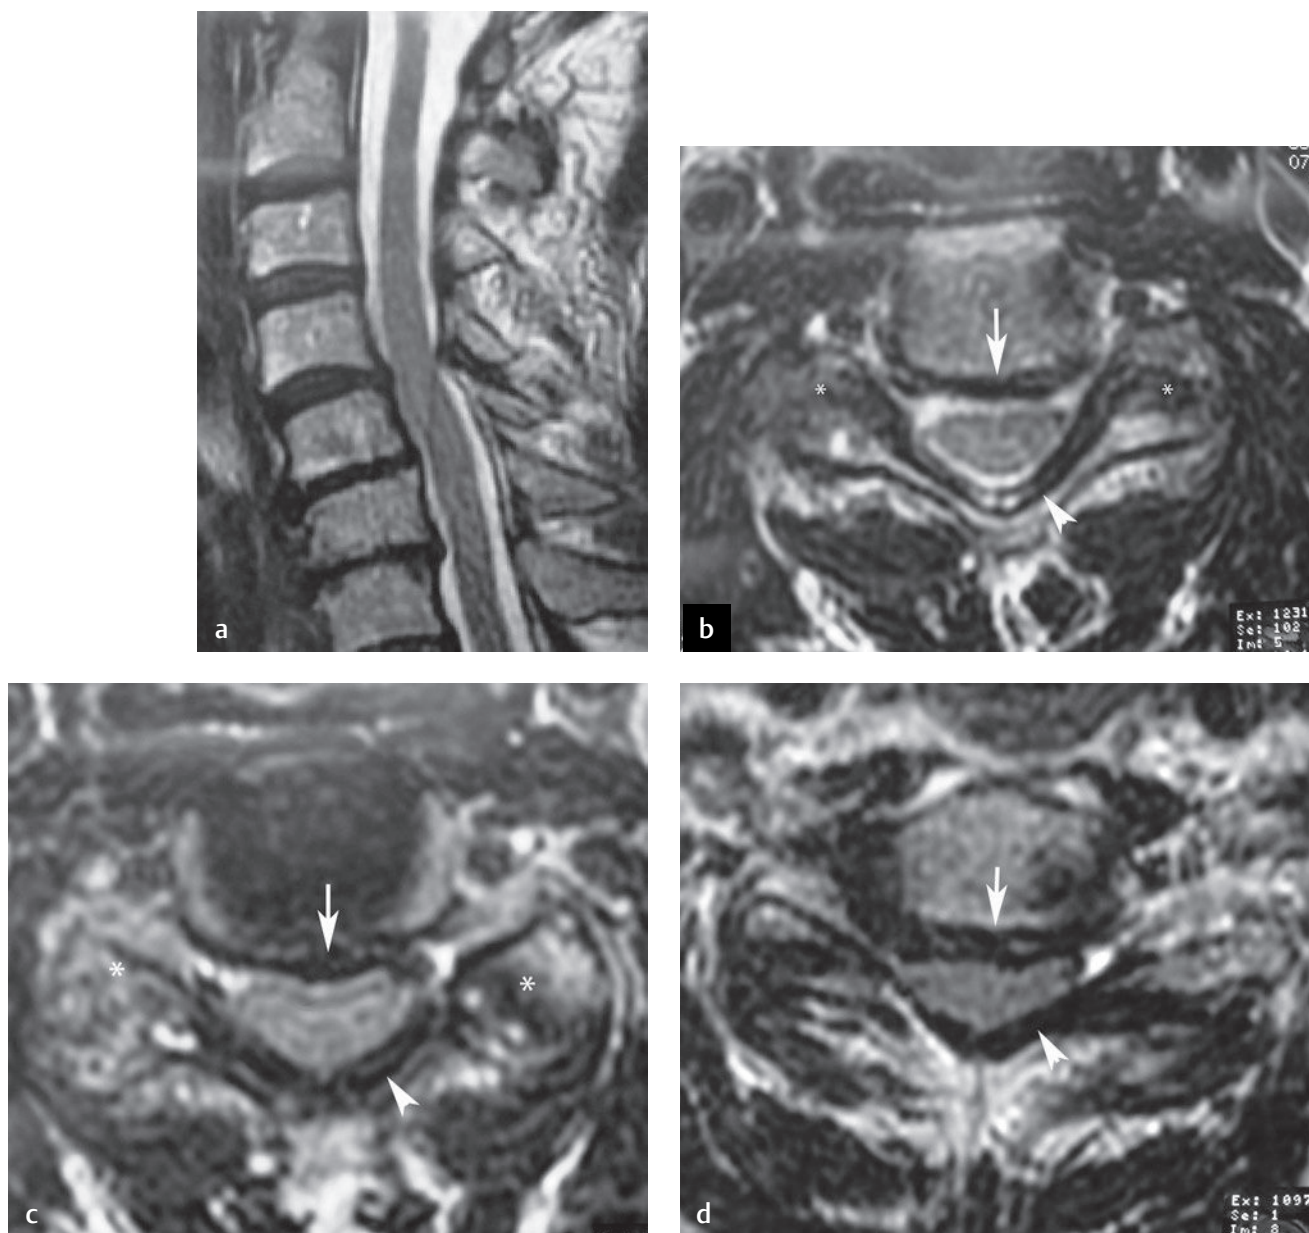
Grading of cervical stenosis: mild to moderate-severe. (a) A sagittal T2-weighted image shows minimal spondylolisthesis at C4-C5 with moderate stenosis at this level. (b) An axial T2-weighted image at the C5-C6 level shows mild stenosis secondary to a central disc bulge (*arrow*), ligamentum flavum hypertrophy (*arrowhead*), and facet arthropathy (*asterisk*). (c) An axial T2-weighted image at the C4-C5 level shows moderate stenosis secondary to more substantial central disc bulge (*arrow*), ligamentum flavum hypertrophy (*arrowhead*), and facet arthropathy (*asterisk*). (d) An axial T2-weighted image (different patient) shows moderate-severe stenosis at the C5-C6 level as a result of even greater central disc bulge (*arrow*) and ligamentum flavum hypertrophy (*arrowhead*).[†]
